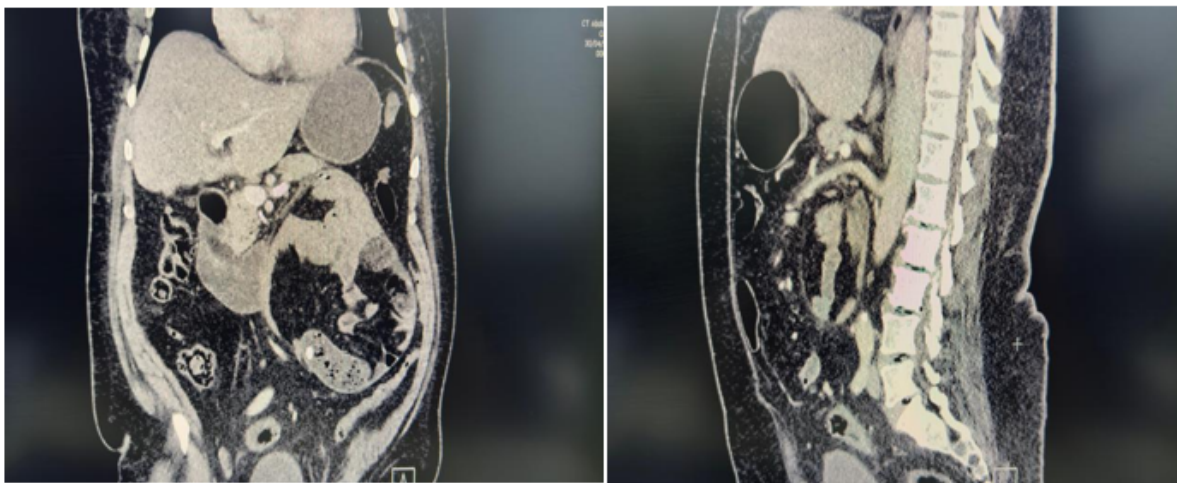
(A): CT showing clustered jejunal loops; (B) Coronal CT demonstrating mesenteric vessel swirling.
